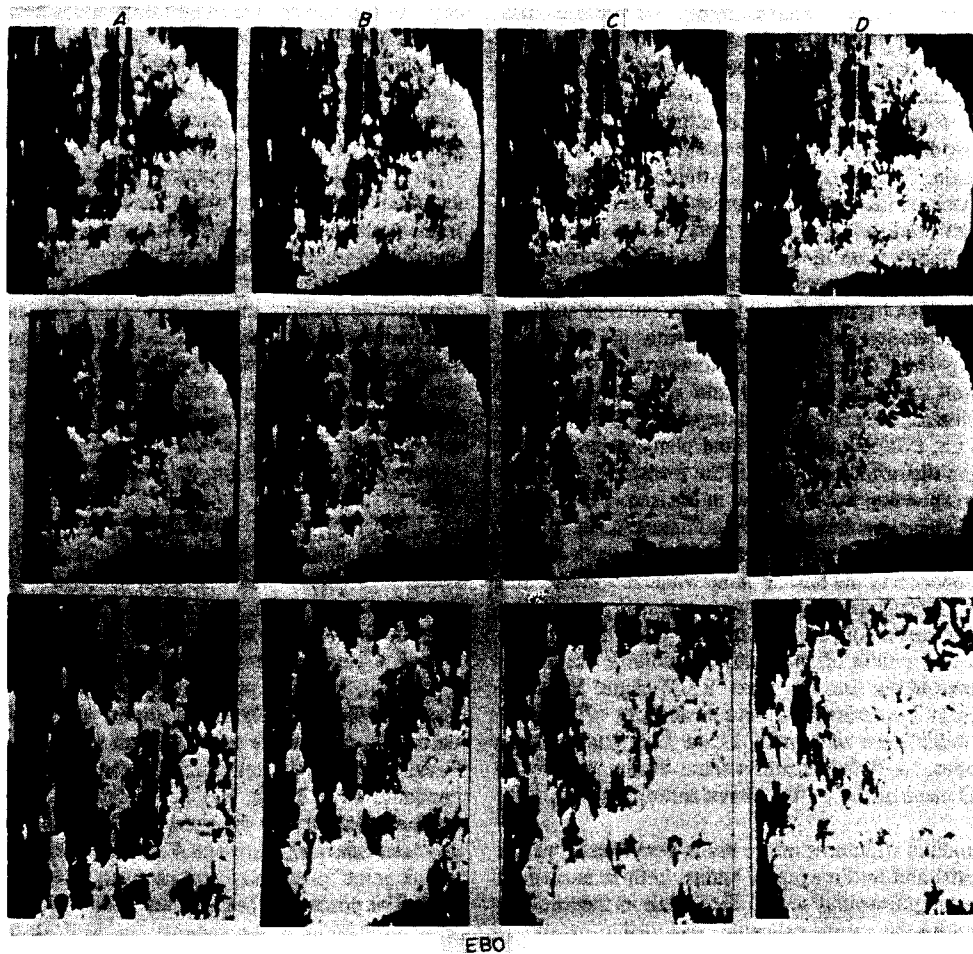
Each of the 12 coronal scans was made at Ear Bar Zero (EBO). The upper row of scans was made with logarithmic amplification for maximal grey scale. Linear amplification combining grey scale with edge enhancement was used for the middle row. Maximal edge enhancement without grey scale was used for the lower row of scans. The upper two rows were made at  $\frac{1}{2}$ :1 magnification. The lower row was made at 1:1 magnification. Gain was increased comparably for each display made from left to right. The heart shaped thalamus-internal capsule interfaces are recognized in each of the scans. The scan beam entering the brain from the right side displays the border of the left thalamus more clearly due to attenuation of the ultrasound beam by passage through tissue. The edge enhancement displayed in the lower row increases the visibility of the thalamic borders. The lateral ventricles are outlined, adjacent to the midline superior to the thalamus, most clearly in the upper two rows under B. The inferior border of the lateral ventricle, adjacent to the thalamus, produces a heavy reflectance. The two walls of the third ventricle could not be resolved. The substantia nigra produces heavy echoes in the inferior portion of the thalamus.
